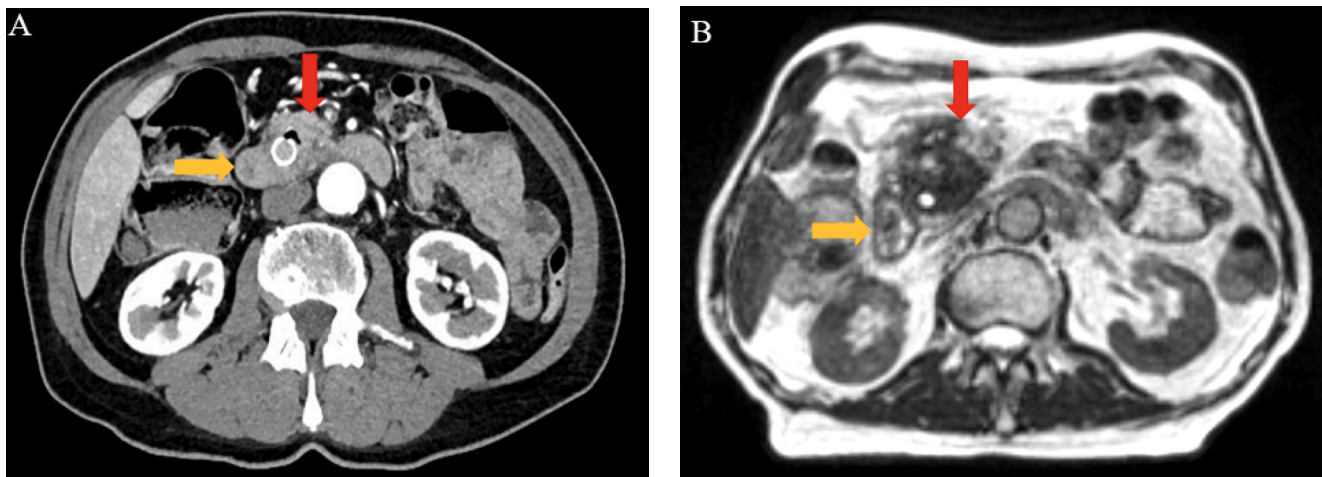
Advantages of MRI-based imaging. A diagnostic CT (A) and MRI-LINAC T2-weighted MRI (B) are demonstrated for a patient with a pancreatic mass. One advantage of using an MRI-LINAC is the improved soft tissue contrast, which can be highly useful when treating disease adjacent to the radiosensitive luminal gastrointestinal tract. Note that the mass (red arrow) is challenging to delineate on CT but appears hypointense on MRI. Additionally, the adjacent duodenum (yellow arrow) is more easily definable on MRI.
